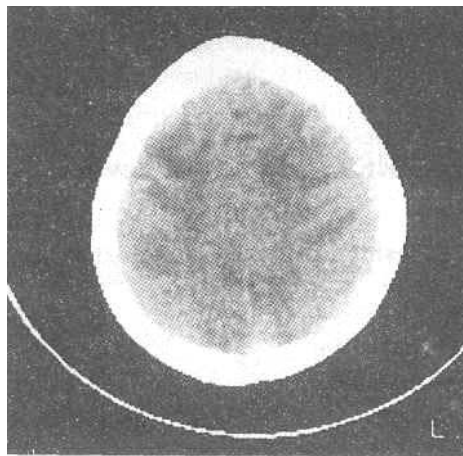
CT scan showing cerebritis.
